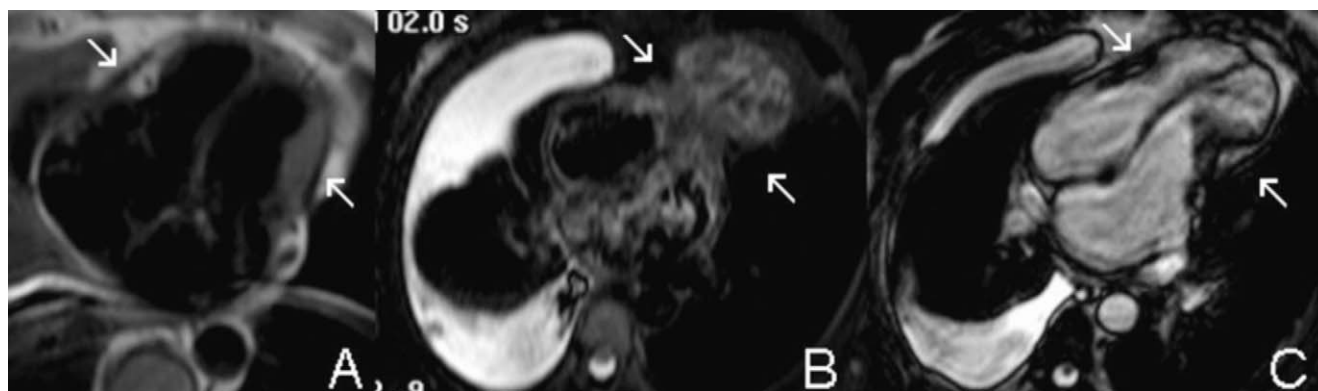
Cardiac magnetic resonance (CMR) imaging in four-chamber view. T1-weighted image (A) shows focally thickened (5 mm) and hypointense (calcified) pericardium at the level of the middle right and left ventricles. T2-weighted image (B) and steady-state free precession cine CMR (C): apical right and left ventricular contractile pseudo-ballooning deformation due to mid-ventricular constriction.
